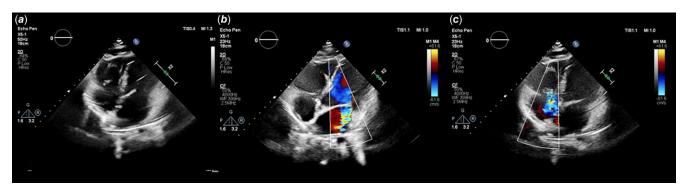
(a) 2D images of the mitral and tricuspid valves after the excising operation of large multiple papillary fibroelastoma lesions. (b) Doppler images of mild to moderate mitral regurgitation jet. (c) Doppler images of mild to moderate tricuspid regurgitation jet.
